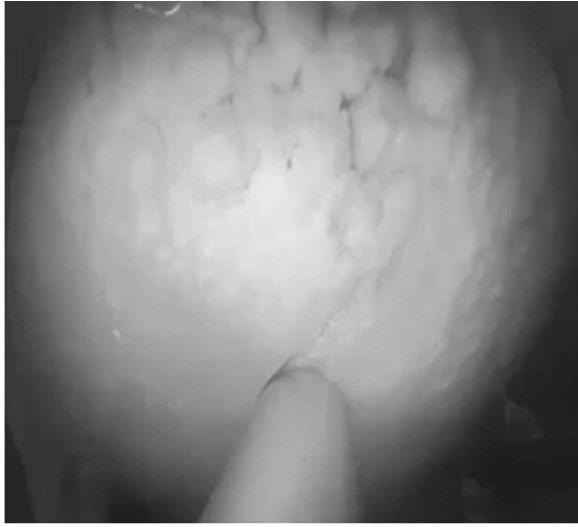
Cystolithiasis encasing the distal end of the ureteral stent pointed by the ultrasonic lithotripter.
